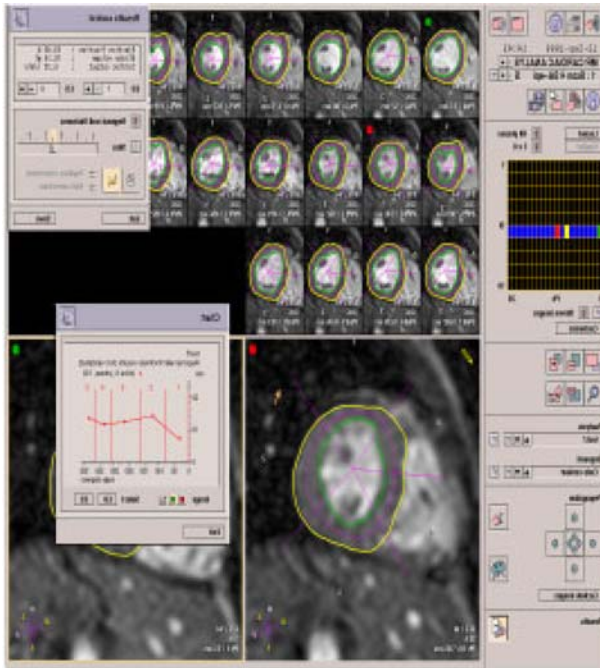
(Color online) EF Measurement in MRI.
